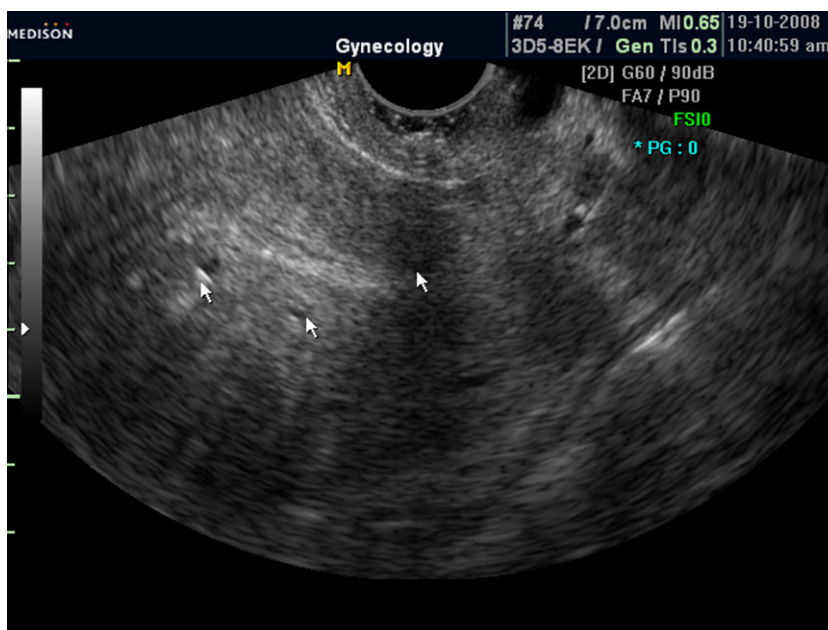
An ultrasound picture of an adenomyotic uterus shows the characteristic ultrasonographic features myometrial cyst (arrow) and linear striations and indistinct endometrial lining.
